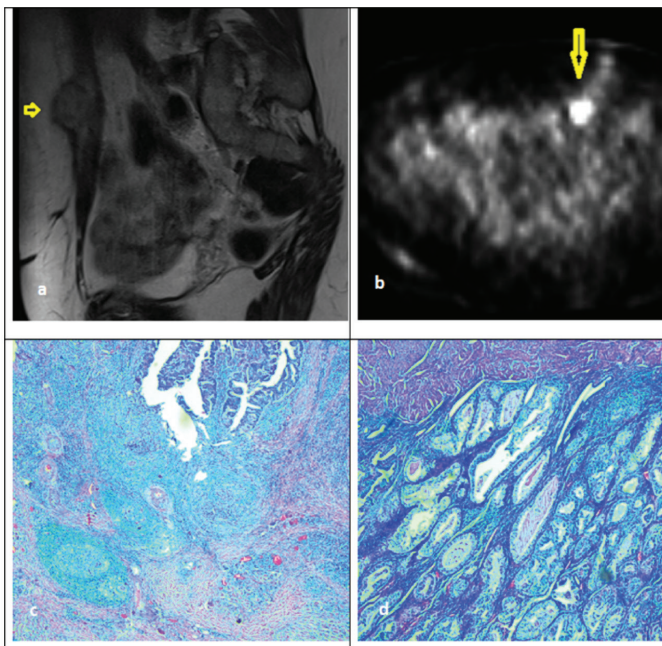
a) Axial section of anterior abdominal wall magnetic resonance imaging, arrow shows residual tumor nodule, b) A positron emission tomography scan showing a residual tumor on the anterior abdominal wall, arrow shows residual tumor on the anterior abdominal wall, c) Pathologic image of endometrioid grade II tumor on the anterior abdominal wall, d) Pathologic image of endometrioid endometrial grade I tumor
